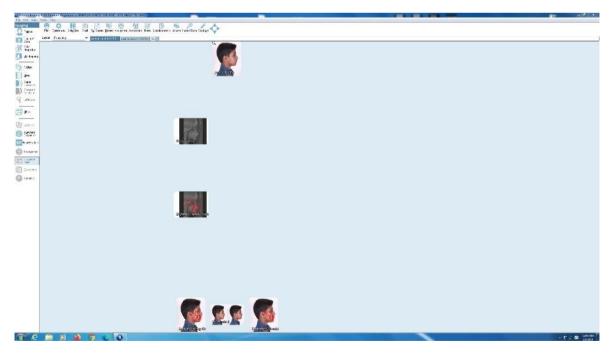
Uploading photographs and radiographs
